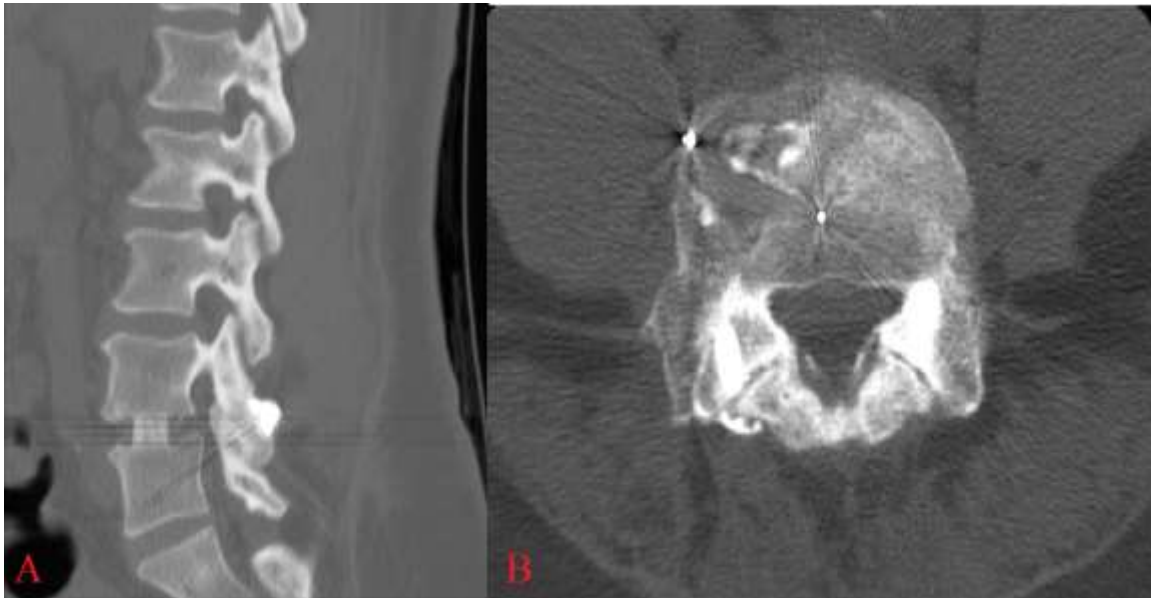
CT demonstrating fusion at L4-L5 A: Sagittal B: Axial.
